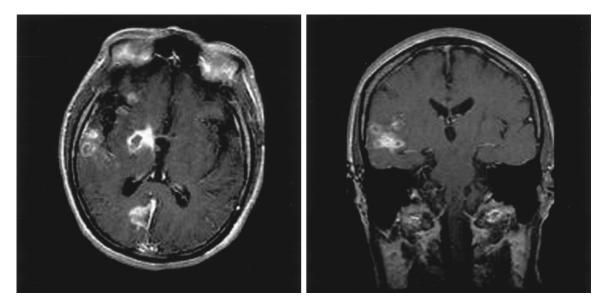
Gadolinium-enhanced axial (*left*) and coronal (*right*) MRI of patient 2 showing numerous right temporofrontal, ring-enhancing lesions in the brain.
